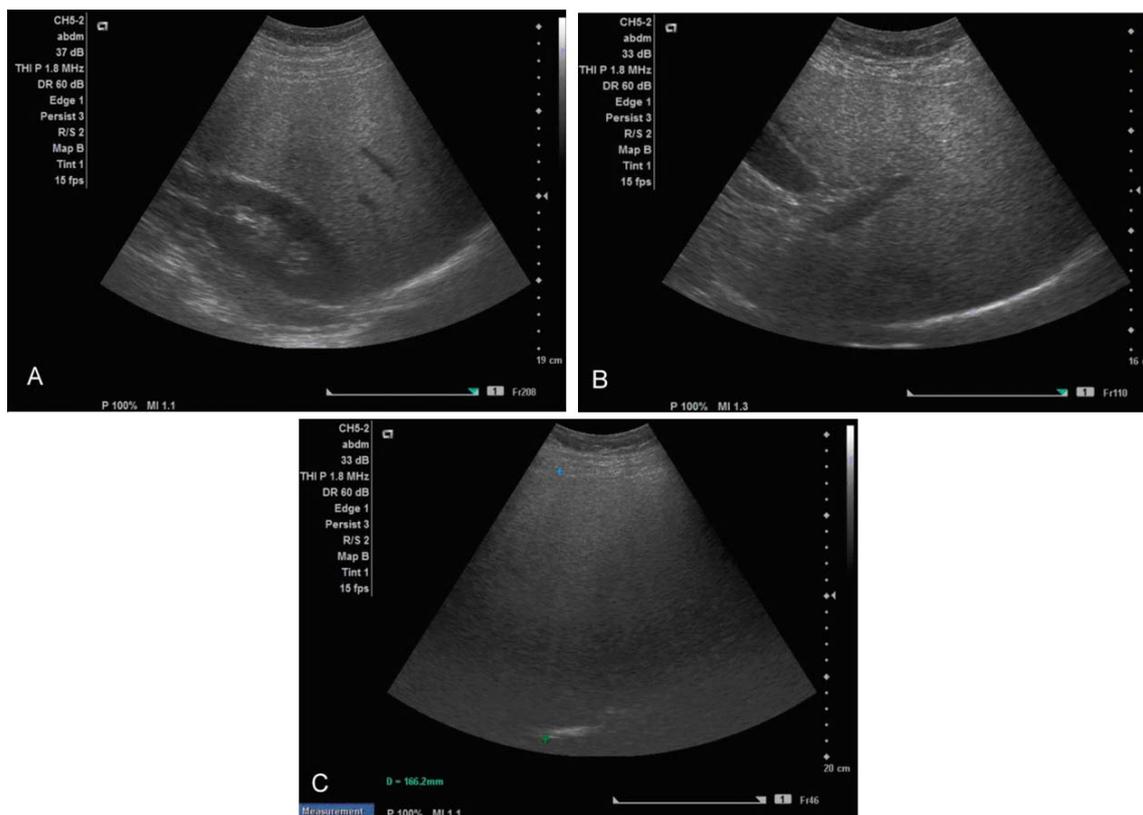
Ultrasound findings of liver steatosis: A) grade 1; B) grade 2, and C) grade 3.
